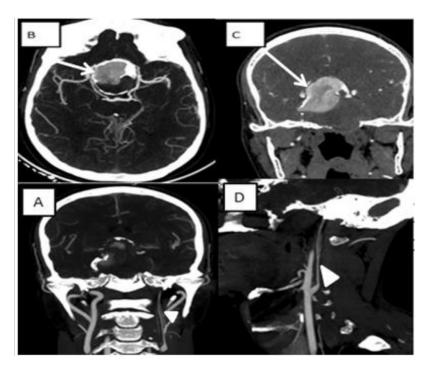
Brain CT with spontaneous contrast and after injection of the iodinated contrast product in the arterial phase in axial (B), and coronal (A, C) and sagittal (D) reconstructions, showing: addition image of the right internal carotid artery (white arrow), heterodense, seat of parietal calcifications, and a marginal thrombus, as well as a central circulating portion (B and C), related to an aneurysm appearing to depend on the intracavernous internal carotid artery, associated with a several stenosis of controlatéral internal carotid artery (arrowhead).
